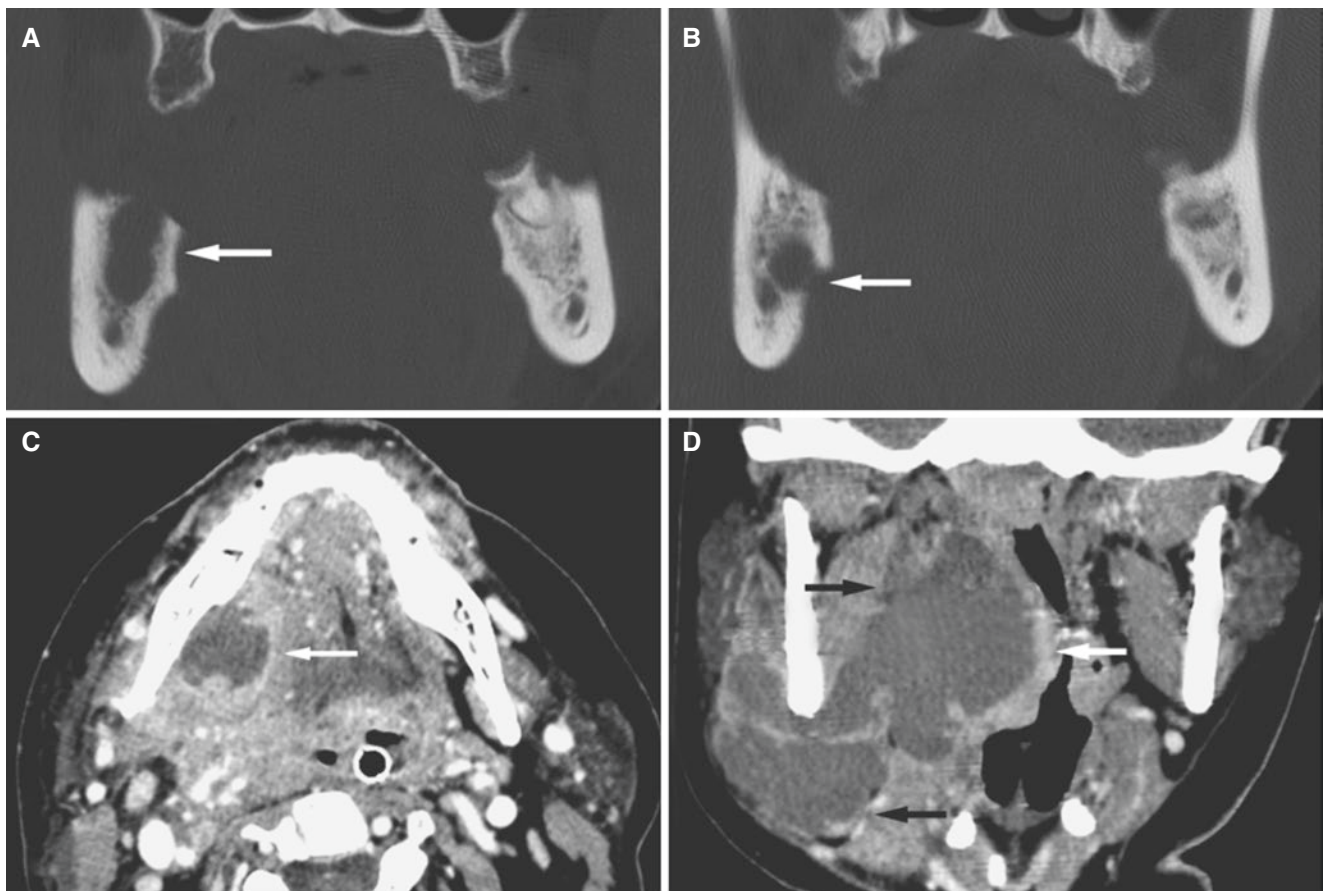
Abscess, parapharyngeal; 29-year-old female with infected third mandibular molar extracted 1 week previously and history of lateral pharyngeal wall infection, large perimandibular swelling, swelling in the floor of the mouth, and air-breathing problems. (A) Coronal post-contrast CT image shows tooth socket (*arrow*) and infectious root also on contralateral side. (B) Coronal post-contrast CT image shows destruction of lingual cortical plate below the attachment of mylohyoid
